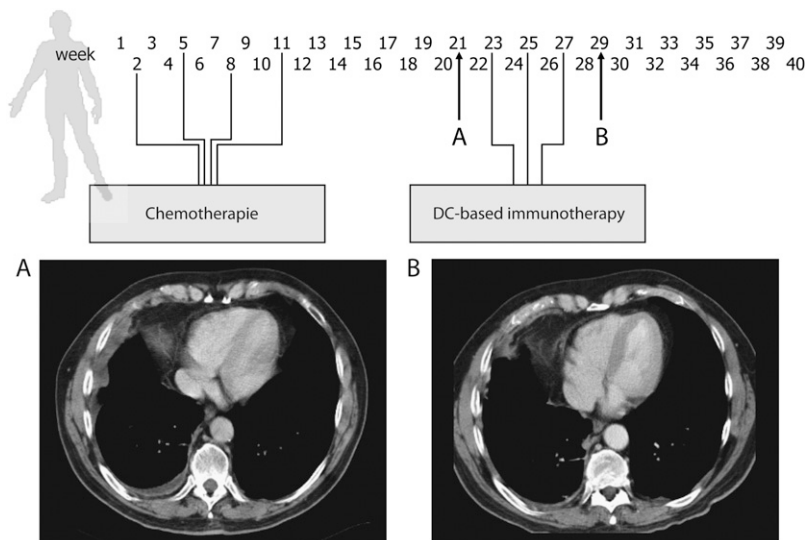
(A) CT scans 2 weeks before the first dendritic cell (DC) vaccination and (B) two weeks after the third vaccination (indicated by arrows on the time scale) revealed a decline in pleural fluid and a regression of the tumor (case 9). Of the 10 participating patients, 6 had progressive disease; 1 had a stable disease, and 3 showed a partial response in this 8-week time period.
